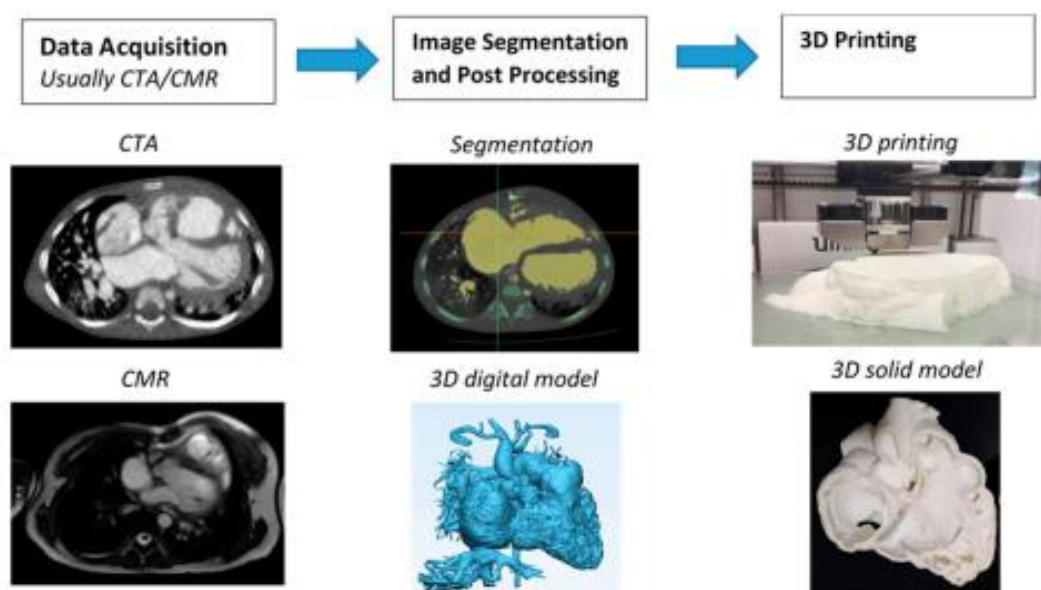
Steps involved in fabrication of 3D printed heart models. CTA—computed tomography angiography; CMR—cardiac magnetic resonance; 3D—three-dimensional.
